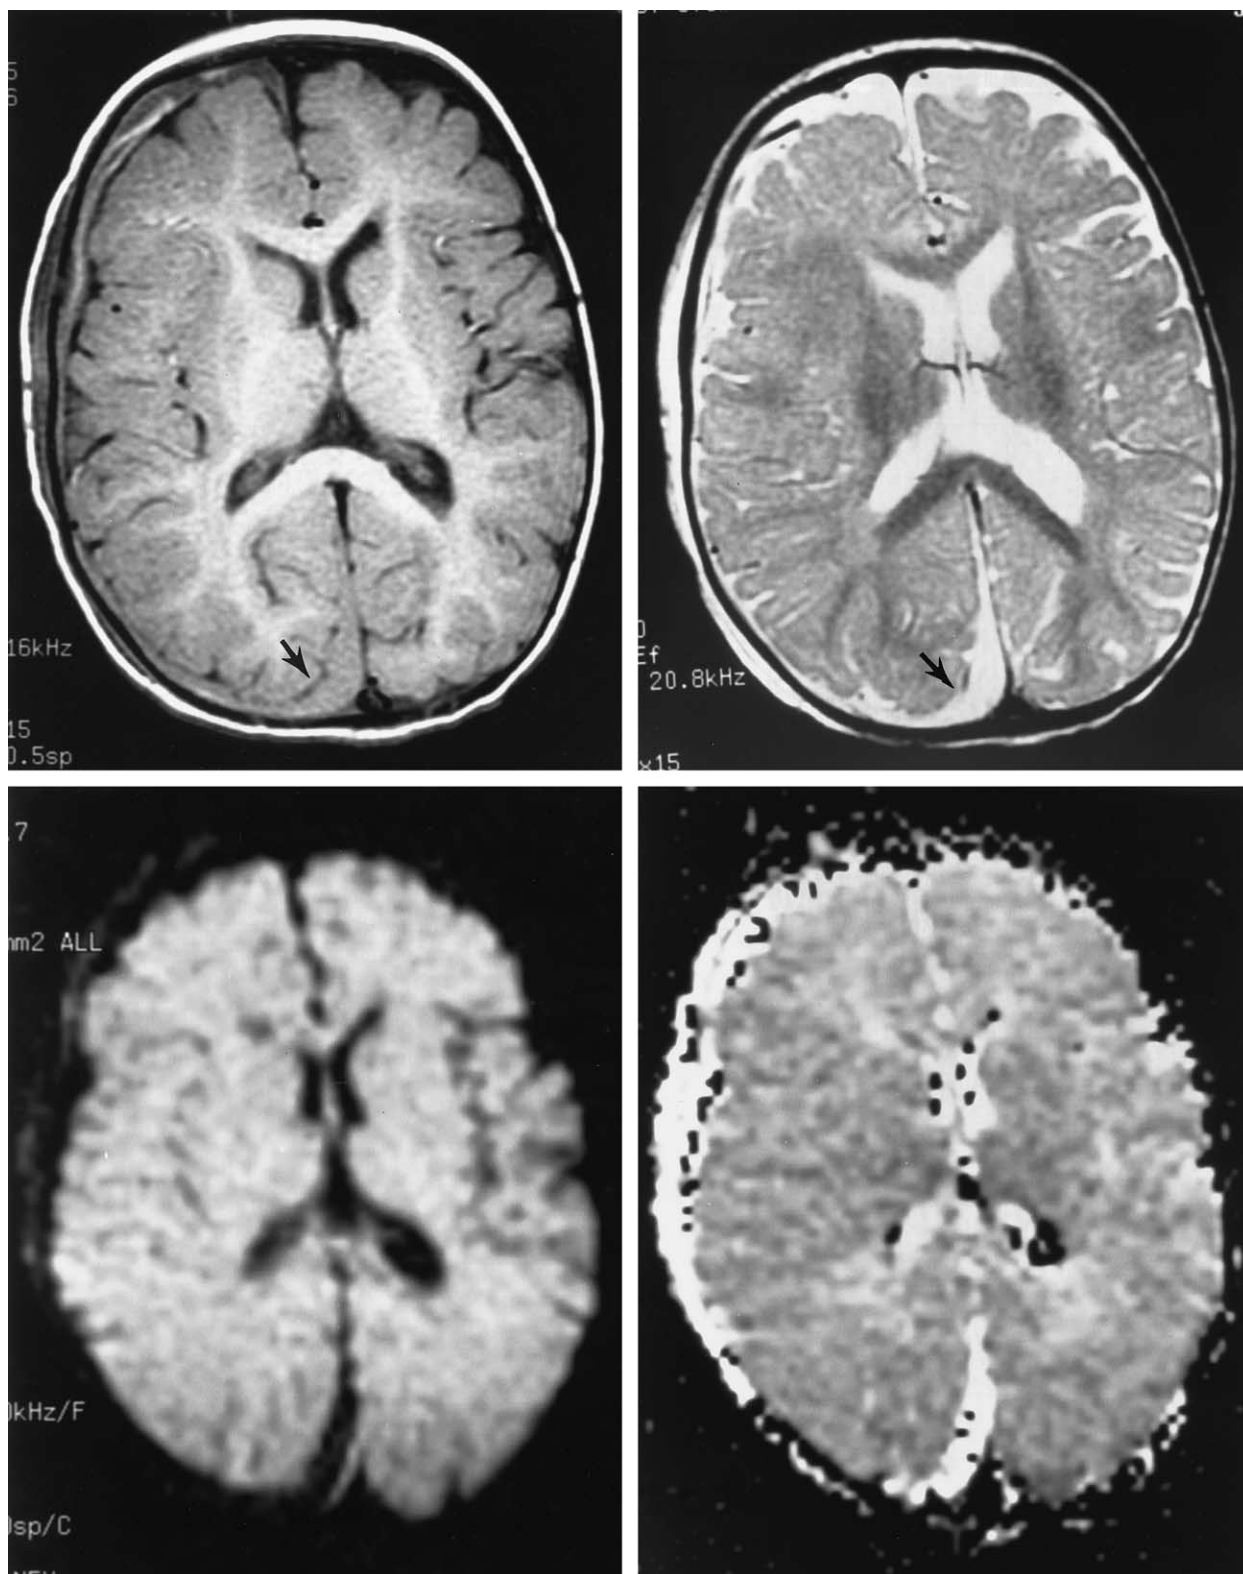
Axial MRI-T1-weighted image (top left), T2-weighted image (top right), diffusion-weighted image (bottom left), and the calculated ADC map (bottom right) obtained 1 day after head trauma in a 7 month-old child with suspected Shaken Baby Syndrome (SBS). There is a subdural hematoma, isointense on the T1-weighted image (arrow) and well seen on the T2W image (top right). The T2-weighted image does not show any associated parenchymal lesion nor do the DWI (bottom left) and ADC map (bottom right), which are unremarkable.
